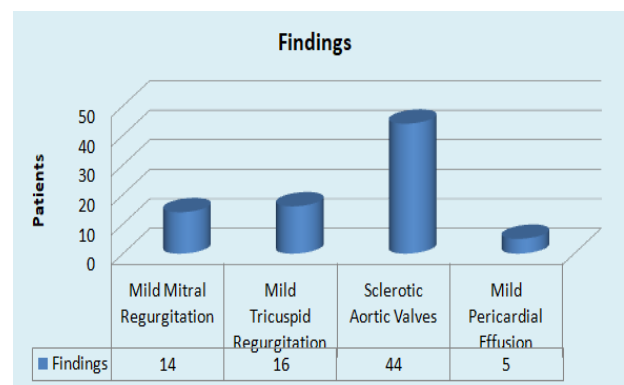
Other findings in 2D echocardiography.
